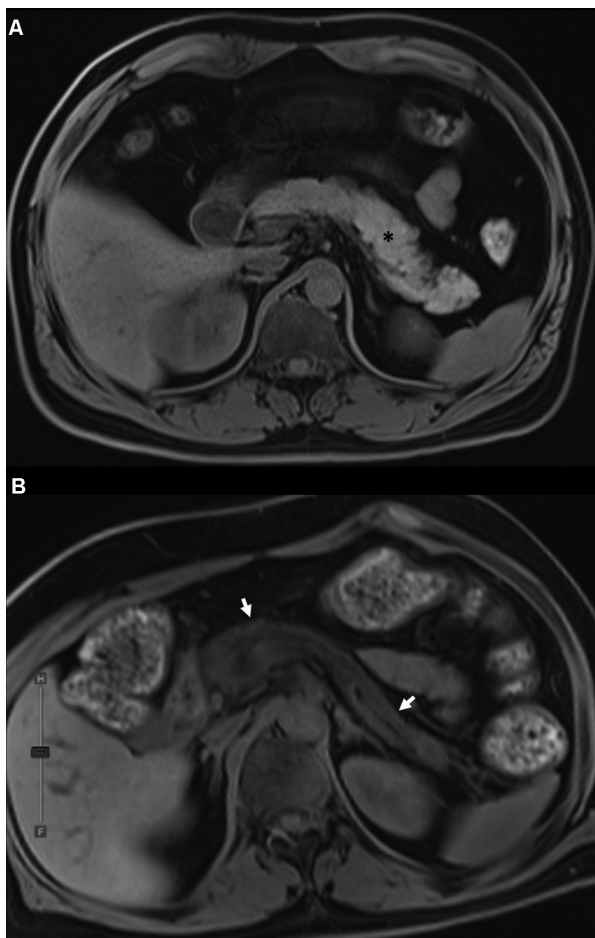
Normal and abnormal appearance of the pancreas on T1-weighted (T1W) fat-suppressed (FS) magnetic resonance imaging (MRI). (A) Normal pancreas in axial plane shows a normal bright signal of the pancreas (black star), as compared to the spleen. (B) Alcohol-related chronic pancreatitis in TRA shows reduced volume of the pancreas and the gland is of low signal intensity (white arrow) as compared to the spleen.
